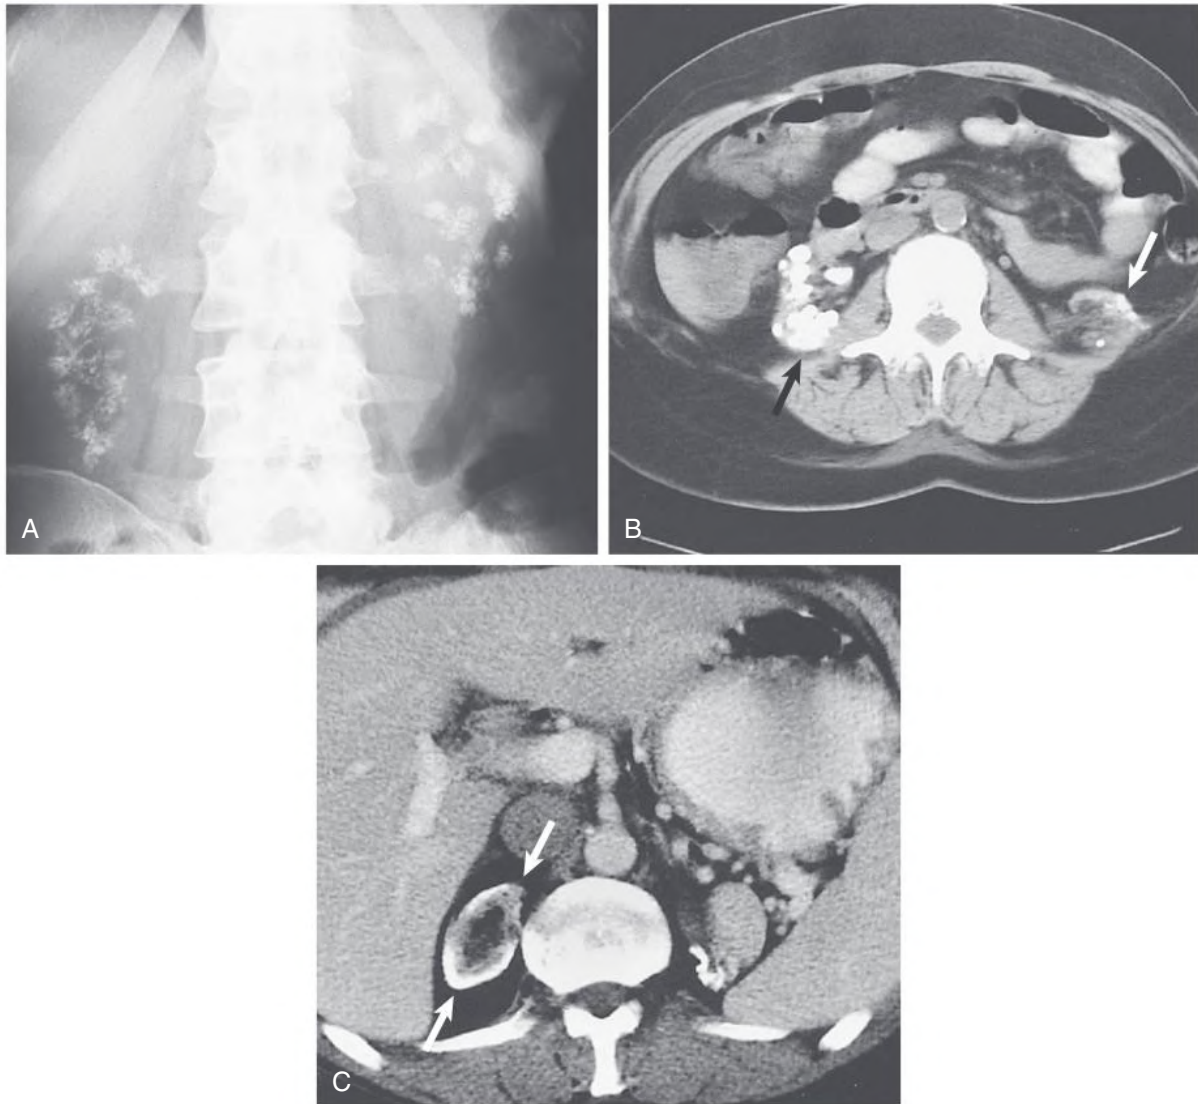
Nephrocalcinosis. (A) Plain radiograph shows bilateral medullary nephrocalcinosis in a patient with distal renal tubular acidosis. (B) Noncontrast computed tomography (CT) scan in a patient with hereditary oxalosis and dense bilateral renal calcification (*arrows*). The left kidney is atrophic. (C) Noncontrast CT scan shows cortical nephrocalcinosis in the right kidney (*arrows*) after cortical necrosis.
